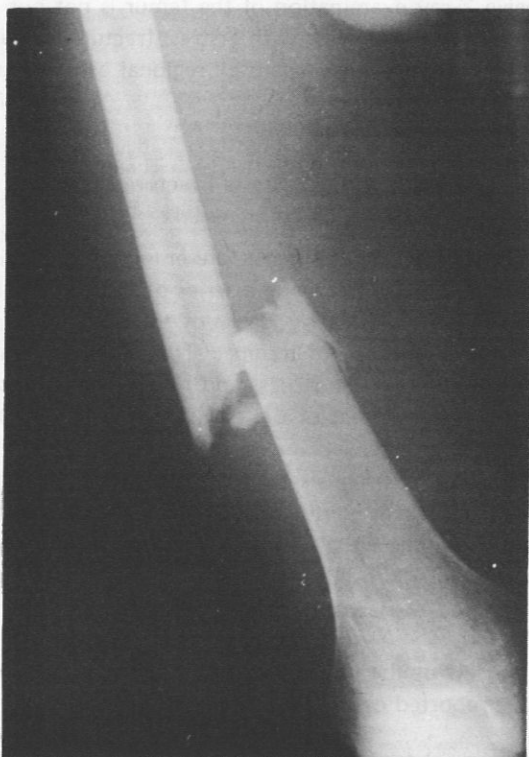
AP X-ray study of the right femur reveals a comminuted stress fracture of the mid-shaft.
